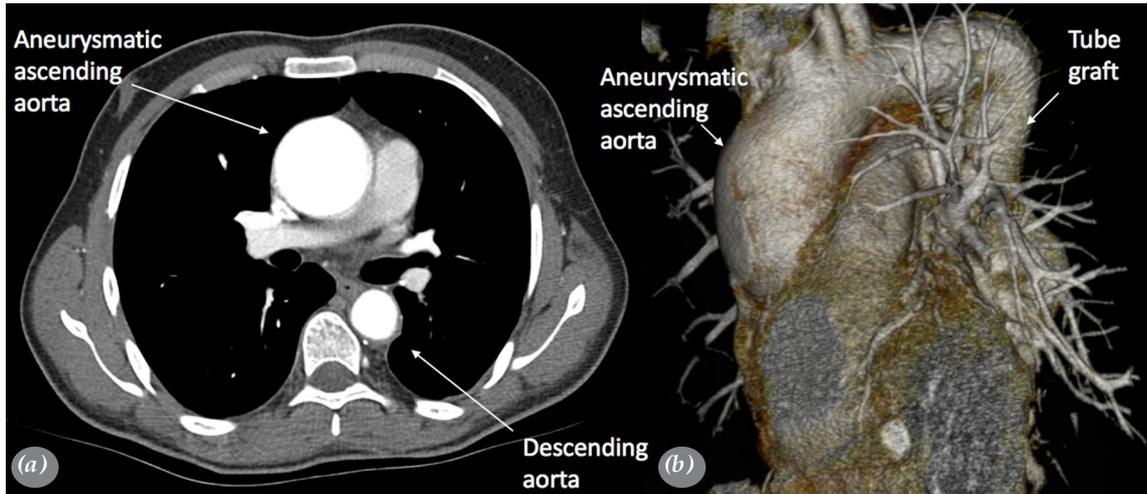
(a) Aneurysm of the ascending aorta is observed on preoperative CTA and (b) its three-dimensional reconstruction.
